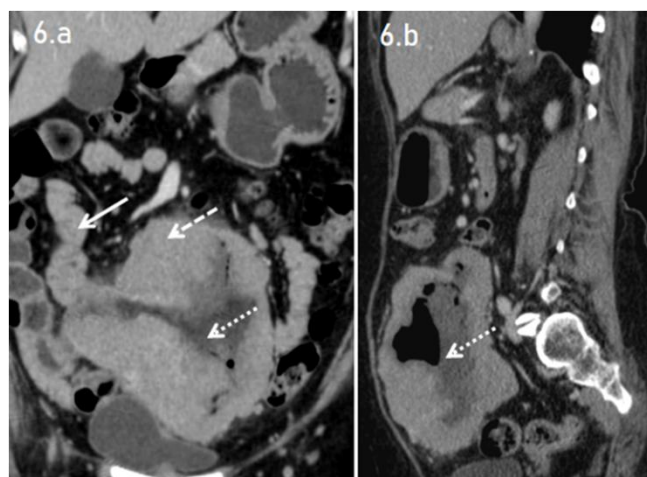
(a & b): 55-year-old case with malignant ileal GIST. Coronal (a) and sagittal (b) views of contrast-enhanced CT study of abdomen in venous show a large circumferential heterogeneously enhancing cavitating mass lesion (dashed arrow) arising from the ileum (solid arrow). The lesion shows central necrosis with air-fluid level (dotted arrow), indicative of the Torricelli-Bernoulli sign. The necrotic cavity is seen communicating with the lumen of the bowel.
